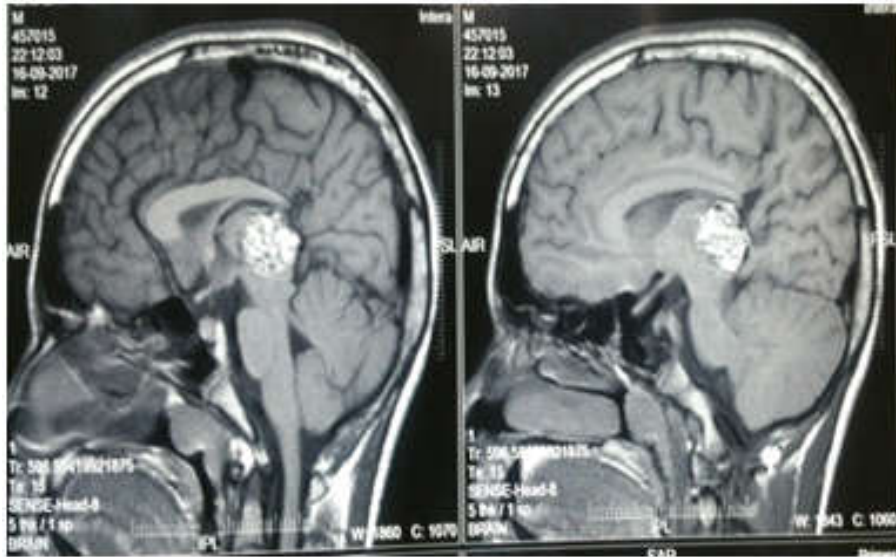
Case Report 2: (a) T1 MRI showing Pineal Cavernoma.
